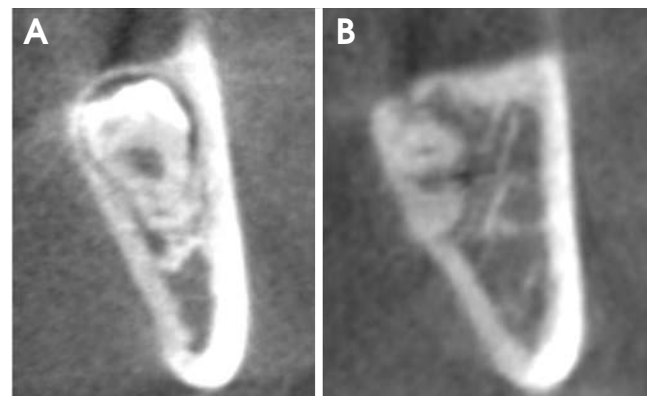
A. Interruption of the mandibular canal wall appears at the border of the mandibular canal where it crosses the third molar on the panoramic radiograph. B. No interruption of the canal wall is seen.
